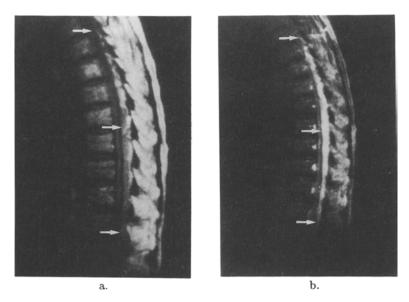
MRI of the thoracic spine 2 hr after the onset of the neurological disorder.
